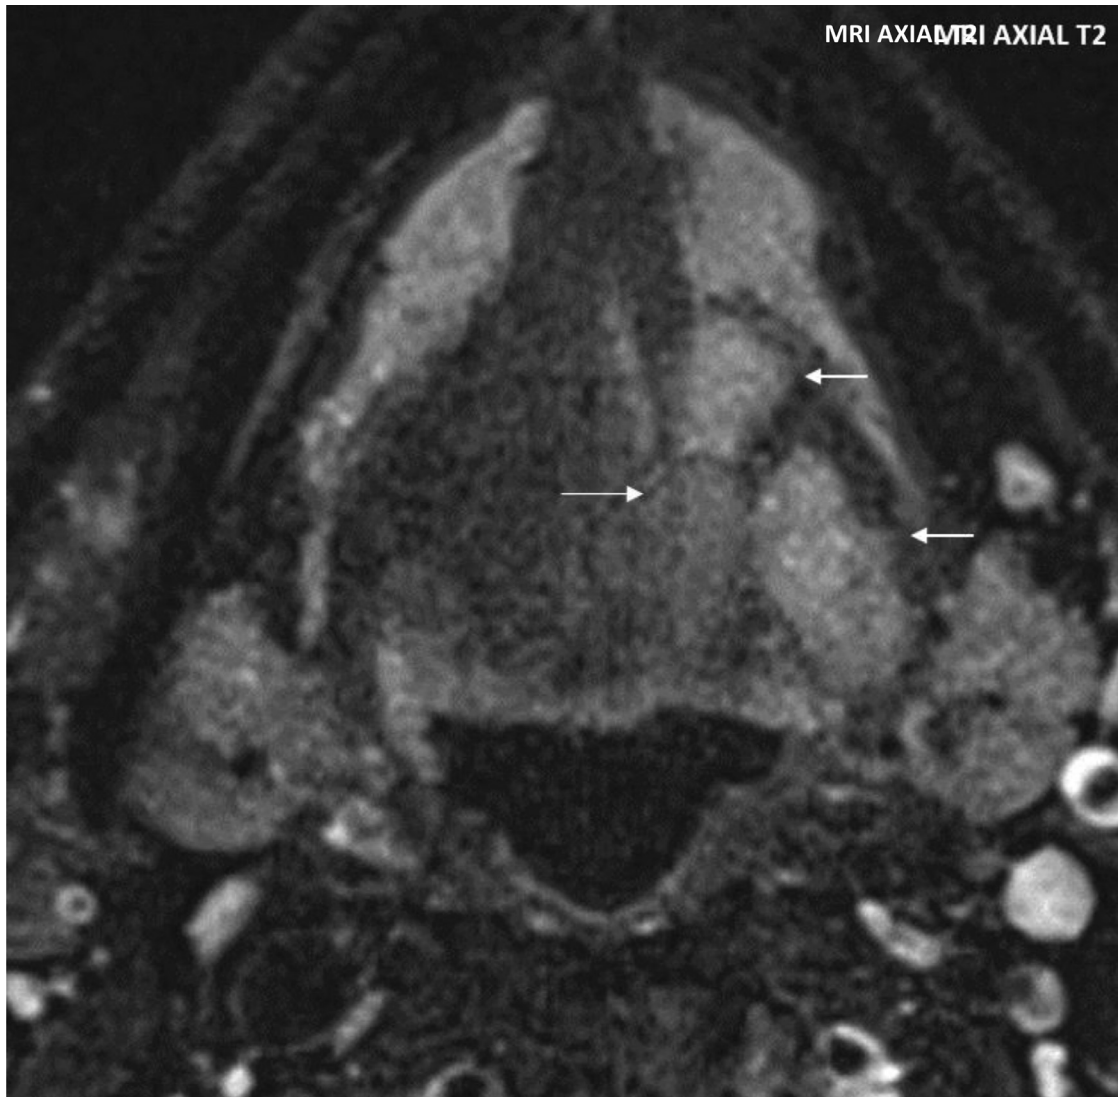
MRI: Axial T2 fat-saturated sequence. Three well-defined T2 hyperintense lesions in the left tongue.
